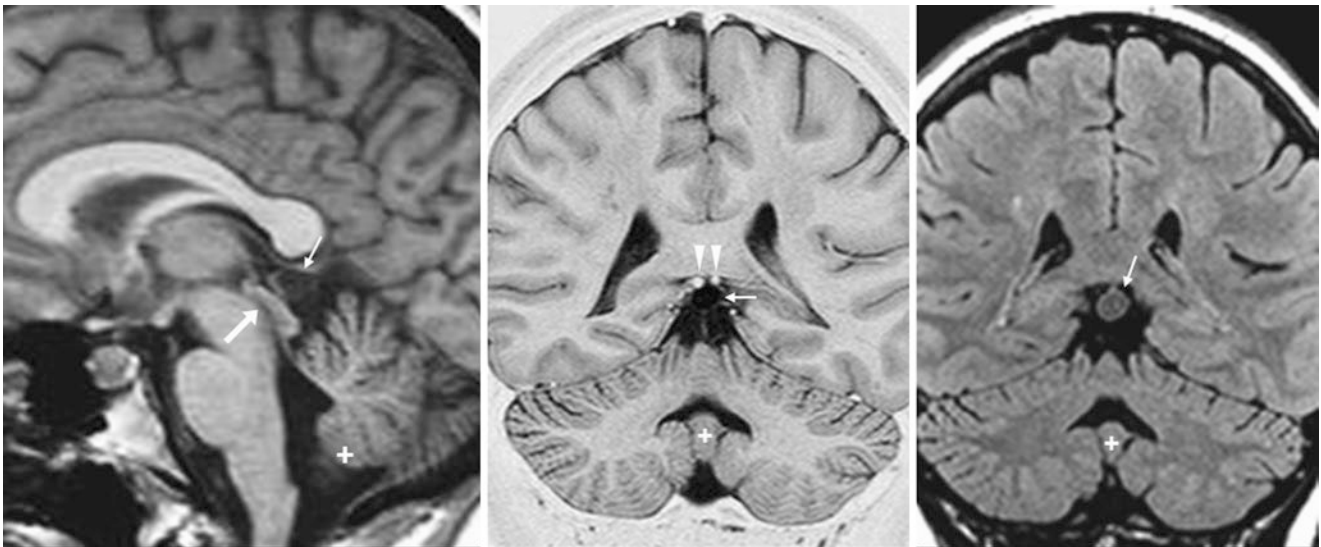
A 28-year-old patient was evaluated for a first time seizure. Present was a small, 9-mm pineal cyst (*thin arrows*) posterior to the tectum and aqueduct (*larger arrows*) shown on 3-mm thickness sagittal T1WI (*left*), coronal T1WI-IR (*middle*), and coronal FLAIR (*right*)
